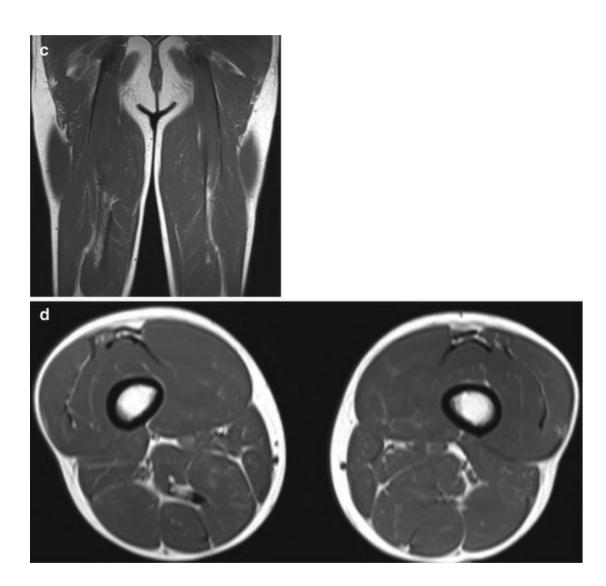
A 30-year-old male professional soccer player with a grade 1 perifascial strain of the left biceps femoris. Feathery interstitial edema is visible within the short head of the biceps femoris on coronal (a) and axial (b) fat-suppressed proton density-weighted MRI. Note also a longitudinal area of low signal intensity in the right semimembranosus muscle on all pulse sequences, better visualized on coronal (c) and axial (d) T1-weighted MRI, indicating scar tissue from a previous strain
